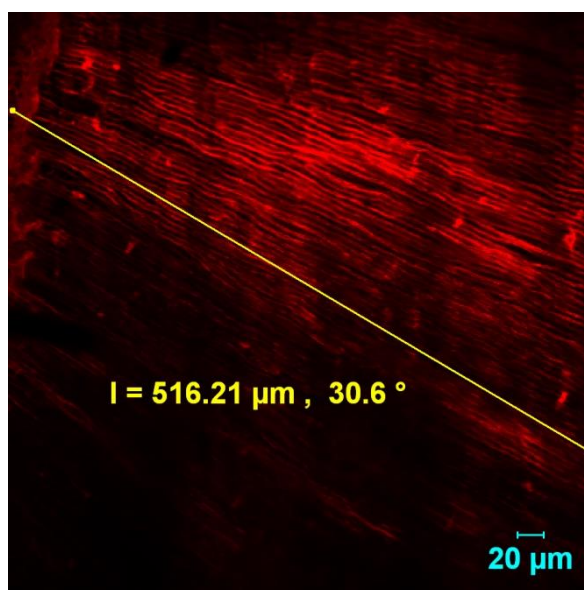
Depth of penetration of root canal sealers into dentinal tubules in the middle portion of Ultrasonic group.
